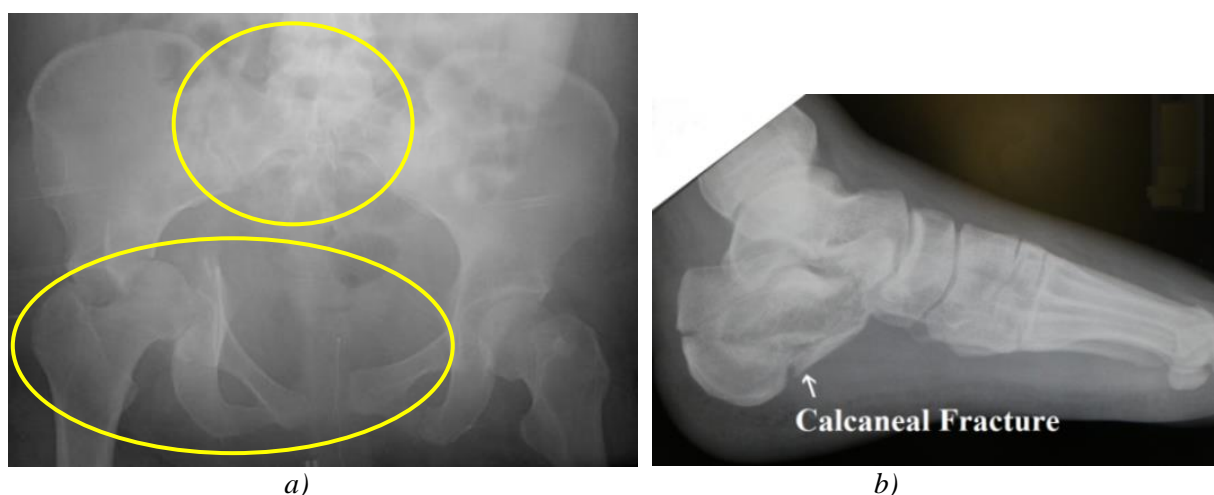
X-ray a) Fracture of pelvis and its acetabulum (anteroposterior radiograph - transverse with posterior wall acetabular fracture), b) X-ray of a depressed calcaneal fracture.
